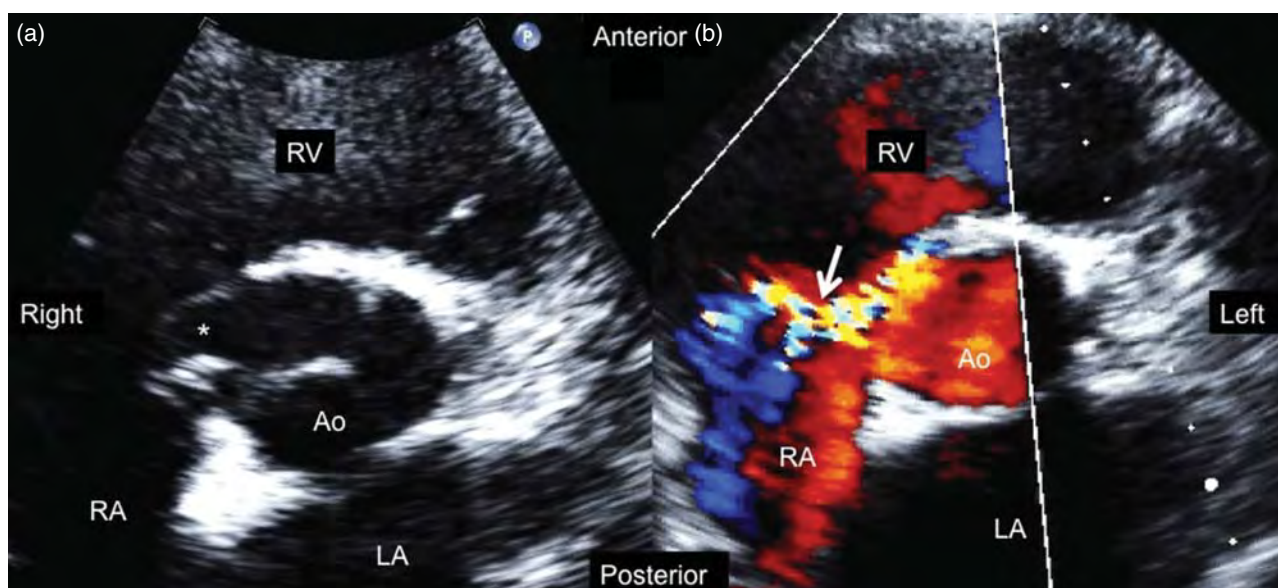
Ruptured right aortic sinus of Valsalva. (a) A two-dimensional, short-axis echocardiographic image of a ruptured sinus of Valsalva aneurysm. Note the tapering of the aneurysm from the aortic end to its right atrial exit (*). (b) A color flow Doppler diastolic image showing the aortic to right atrial shunt (arrow). Note that there are actually two defects (ruptures) in the distal sinus, creating a “Y-shaped” color jet. The exit was into the right atrium, so the shunt flow was continuous in this case. Ao, aorta; LA, left atrium; RA, right atrium; RV, right ventricle.
